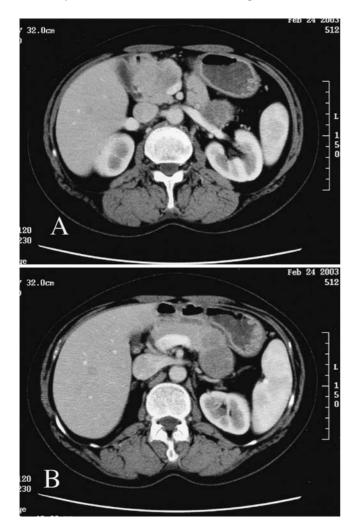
Computed tomography (CT) shows tumors in A the pancreatic head and B pancreatic body
